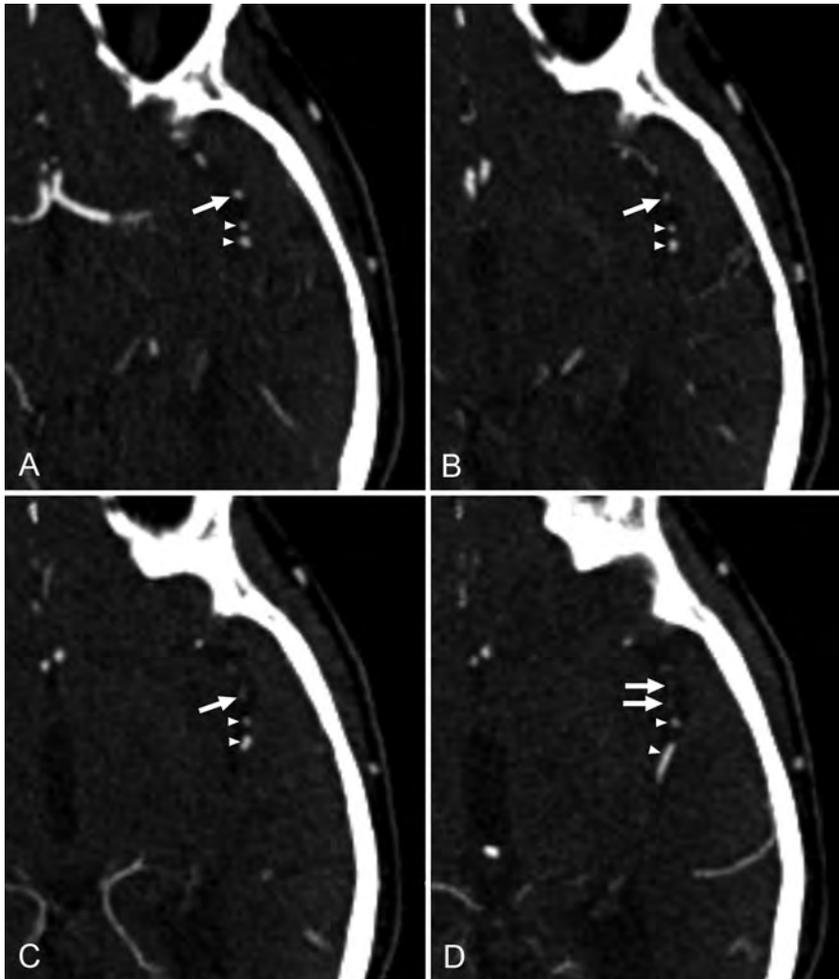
A 75-year-old male patient with acute ischemic stroke. At initial CTA evaluation, occlusion of 1 of the M2 segment branches of the left middle cerebral artery (arrows on all slices) was missed. Consecutive axial CTA slices in a caudocranial direction (A–D) show a contrast filling defect in a branch of the left M2 segment (arrows in C and D). Note that 2 adjacent branches of the left M2 segment show normal contrast filling on all slices (arrowheads).
